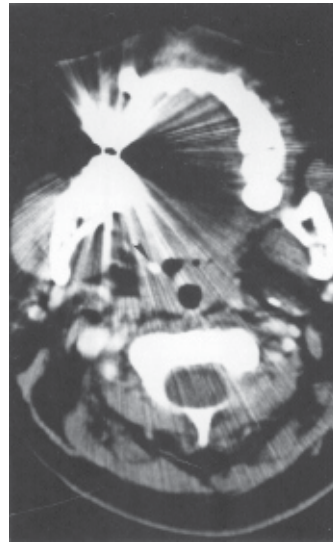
Computed tomography scan of the neck of a 55-year-old Chinese woman showing a calcified density in the right pharyngeal wall, suspicious of a foreign body.
